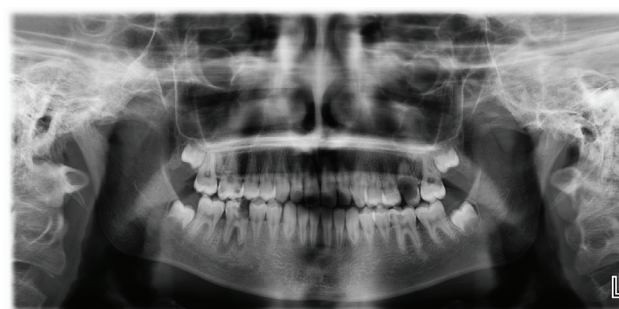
In the panoramic radiograph of a patient who received treatment for Ewing sarcoma, root shortening is present in all teeth
